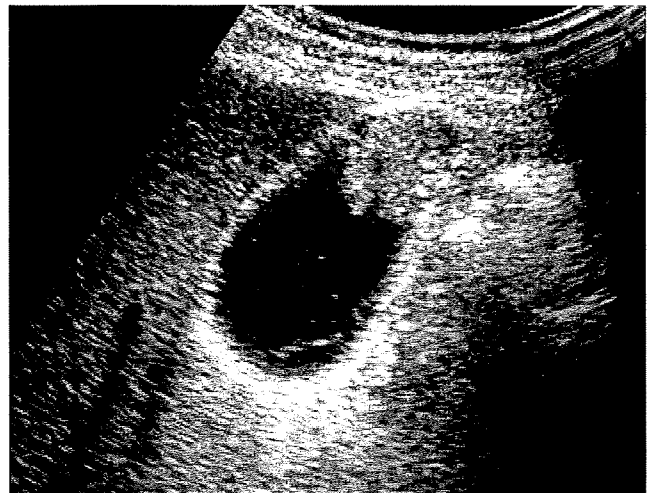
Ultrasound image of early-stage gallbladder carcinoma: a pedunculated protrusion with a relatively high echoic signal. Depth of tumor invasion is limited to the mucosal layer
